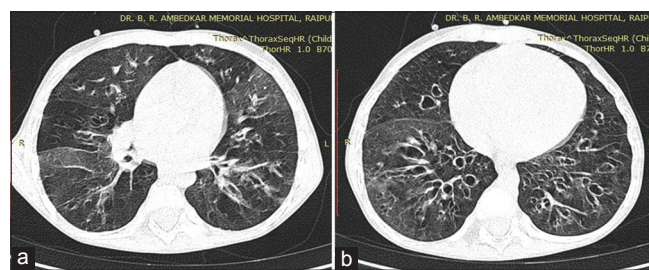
HRCT axial images showing patchy ground-glass opacity with mosaic attenuation (a) and bronchiectatic changes diffusely involving bilateral lower lung likely suggestive of bronchiolitis obliterans (b)
